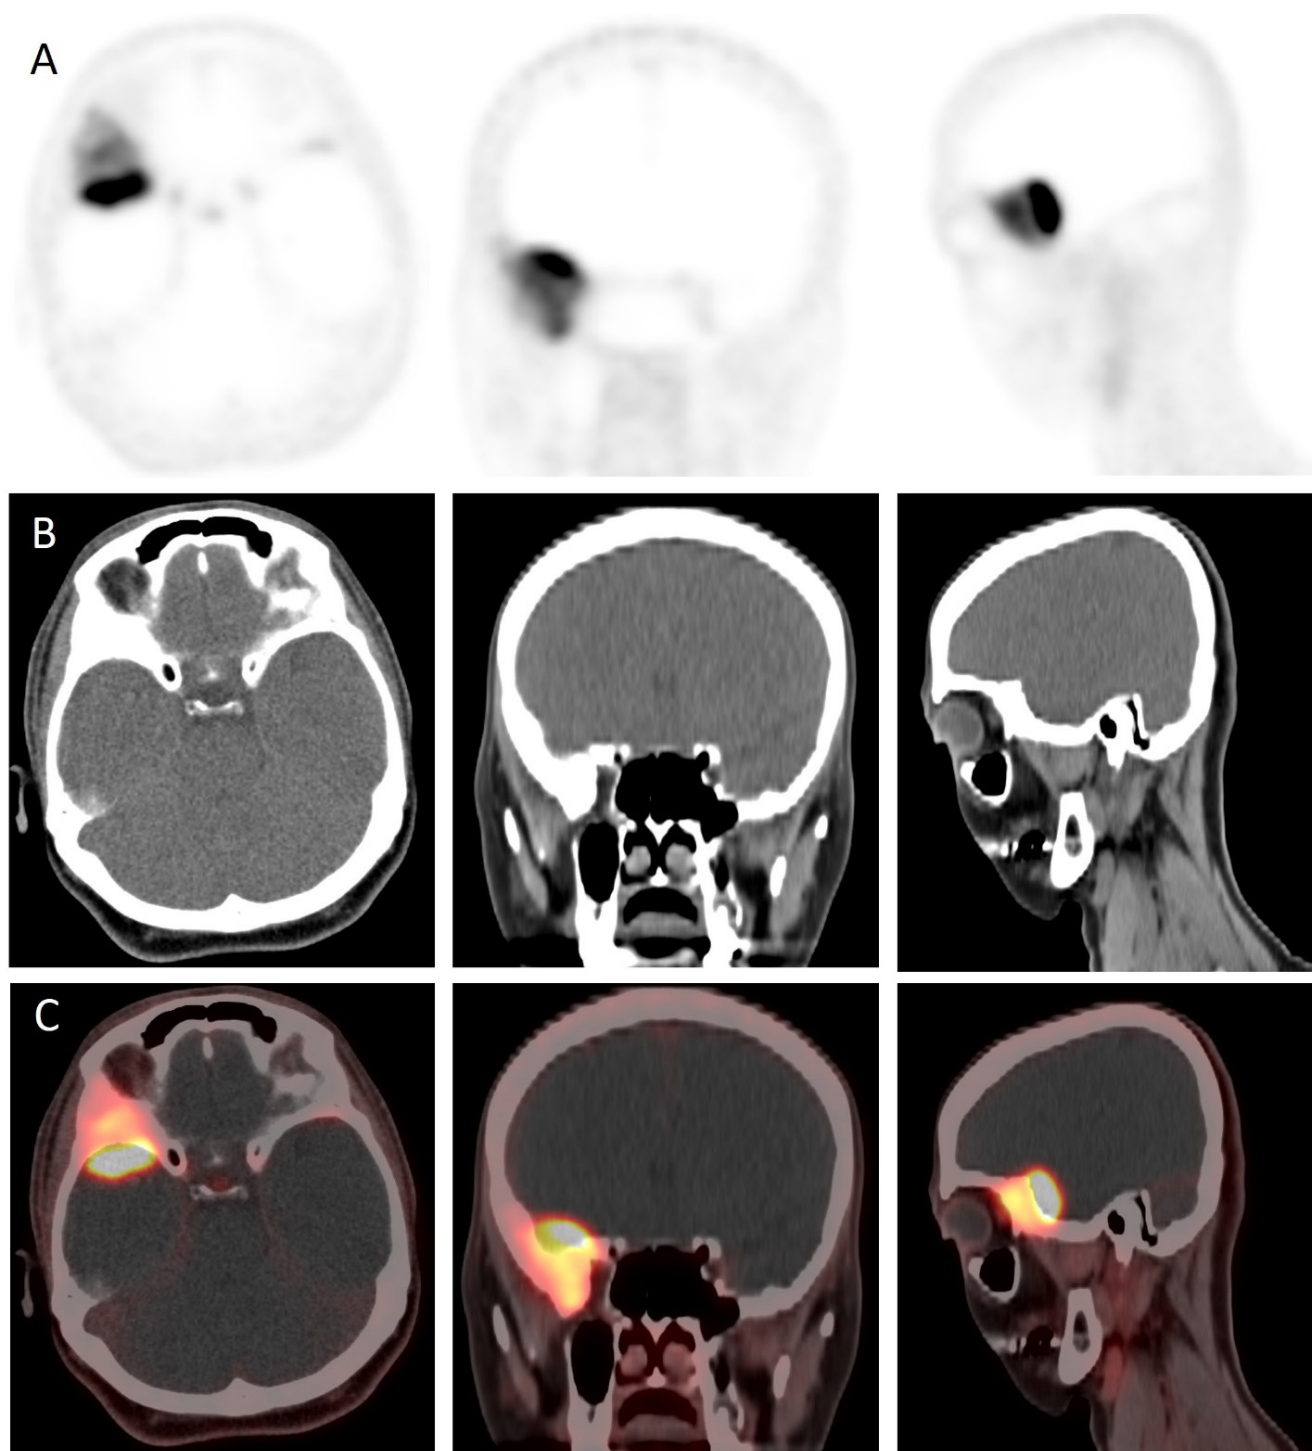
A 48-year-old woman with right orbital pain and swelling was diagnosed with meningioma of the right sphenoid wing on magnetic resonance imaging (MRI). Gallium-68 (^{68}Ga)-DOTA positron emission tomography/computed tomography (PET/CT) was performed for tumor delineation and lesion characterization. A-C ^{68}Ga -DOTA TOC PET/CT images demonstrate an extraaxial focal area of increased tracer uptake (SUV_{max}: 17.5) along the right sphenoid region/right anterior temporal region.
